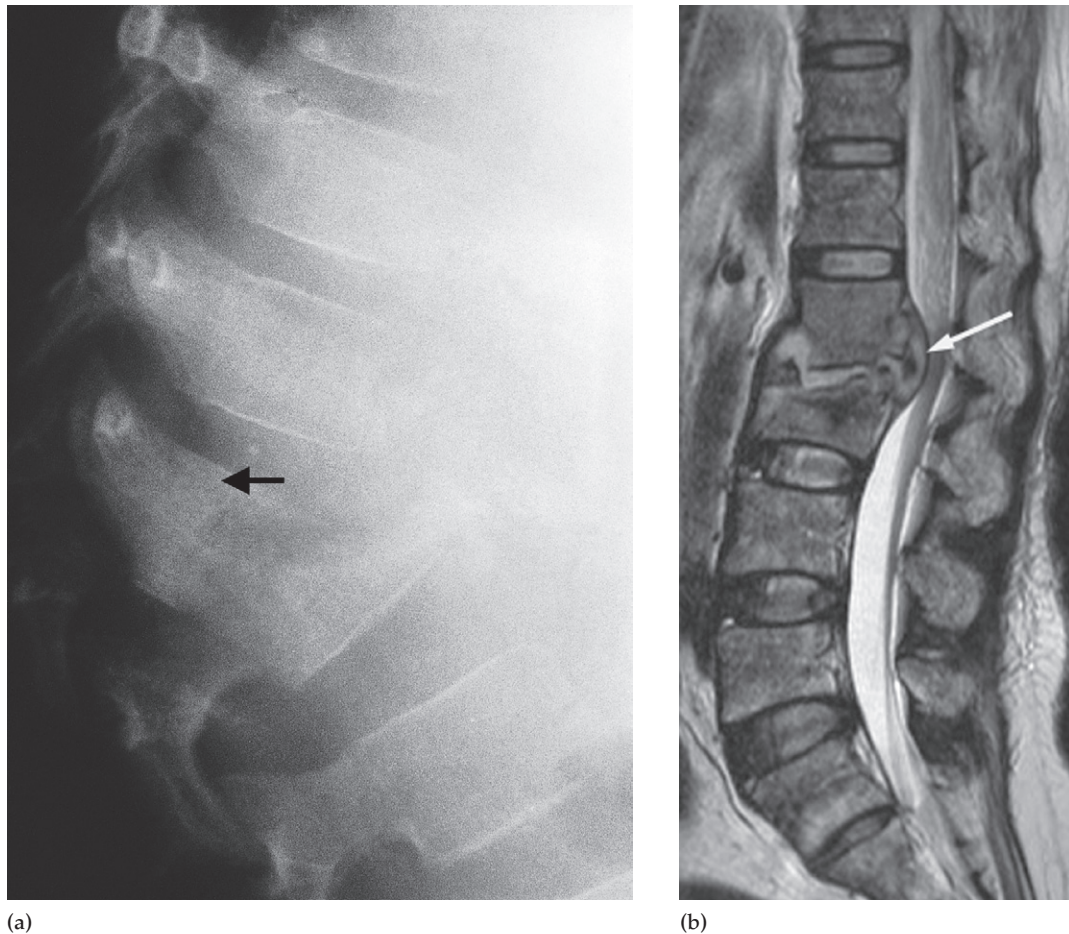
Tuberculosis of the spine. (a) Plain film showing destruction of the vertebral bodies and the intervening discs with the formation of a sharp angulation (gibbus). One vertebral body is almost completely destroyed (arrow) and there is destruction of the upper part of the one below it. (b) T2-weighted MRI in another patient showing destruction of the intervertebral disc and part of the vertebral body below it. A large inflammatory mass is protruding into the spinal canal causing compression of the cauda equina (arrow).
